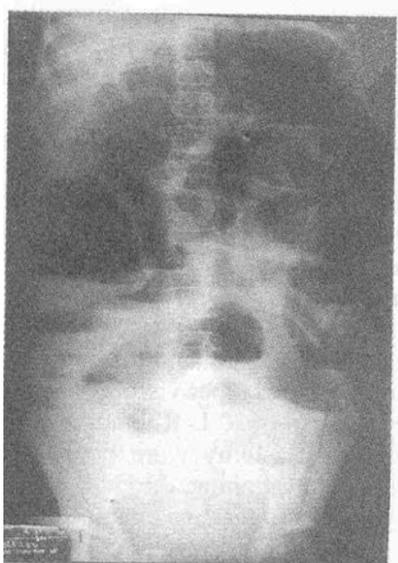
Abdominal X-ray suggestive of left sided colonic obstruction.
